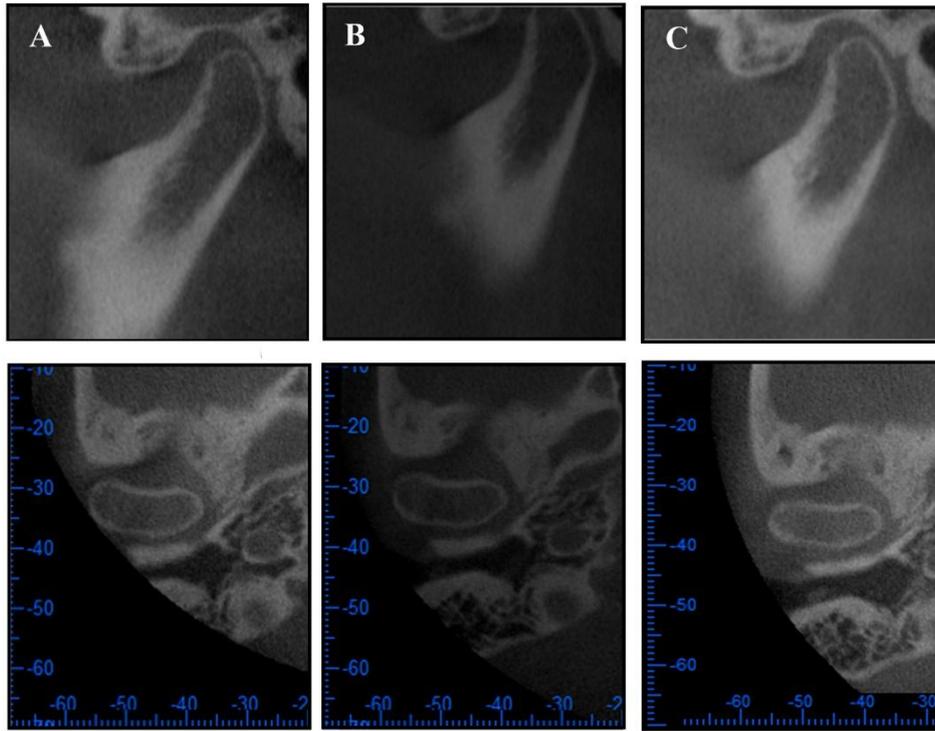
Pretreatment (A), posttreatment (B), and 22-month retention (C) CBCT images of the right TMJ in the sagittal (upper) and transverse (lower) planes.
